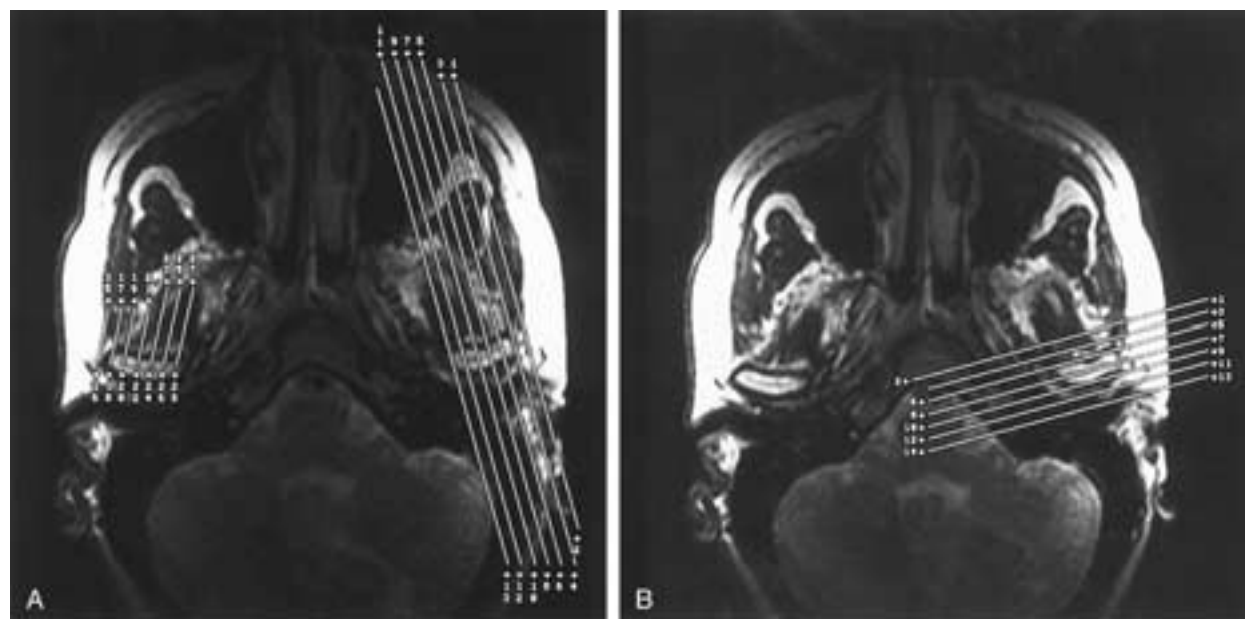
Axial scout images for sagittal (A) and coronal (B) MR images. The orientations of the sagittal and coronal images are outlined. It is important to cover the area of the lateral and medial poles of the condyle with the sagittal images. For the coronal images, one image should be through the center of the condyle.
